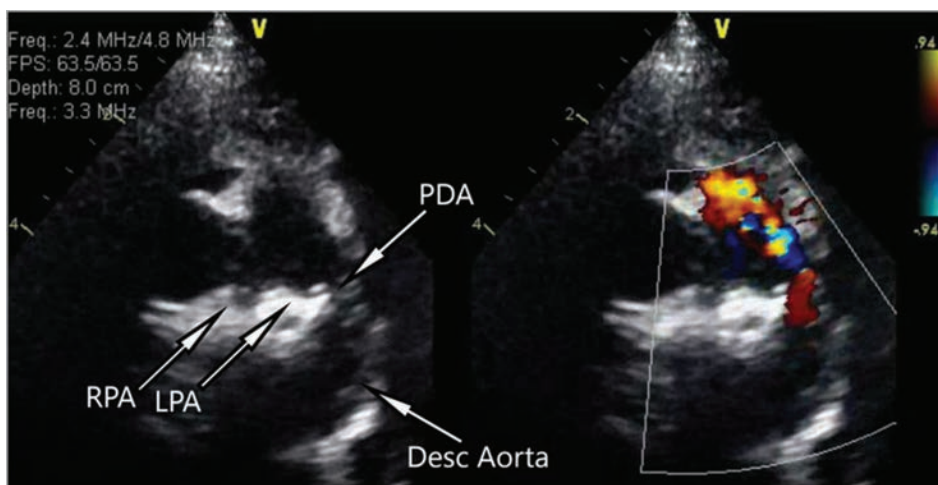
High-parasternal color-compare short-axis echocardiographic view (“3-finger view”) demonstrating a small PDA.
